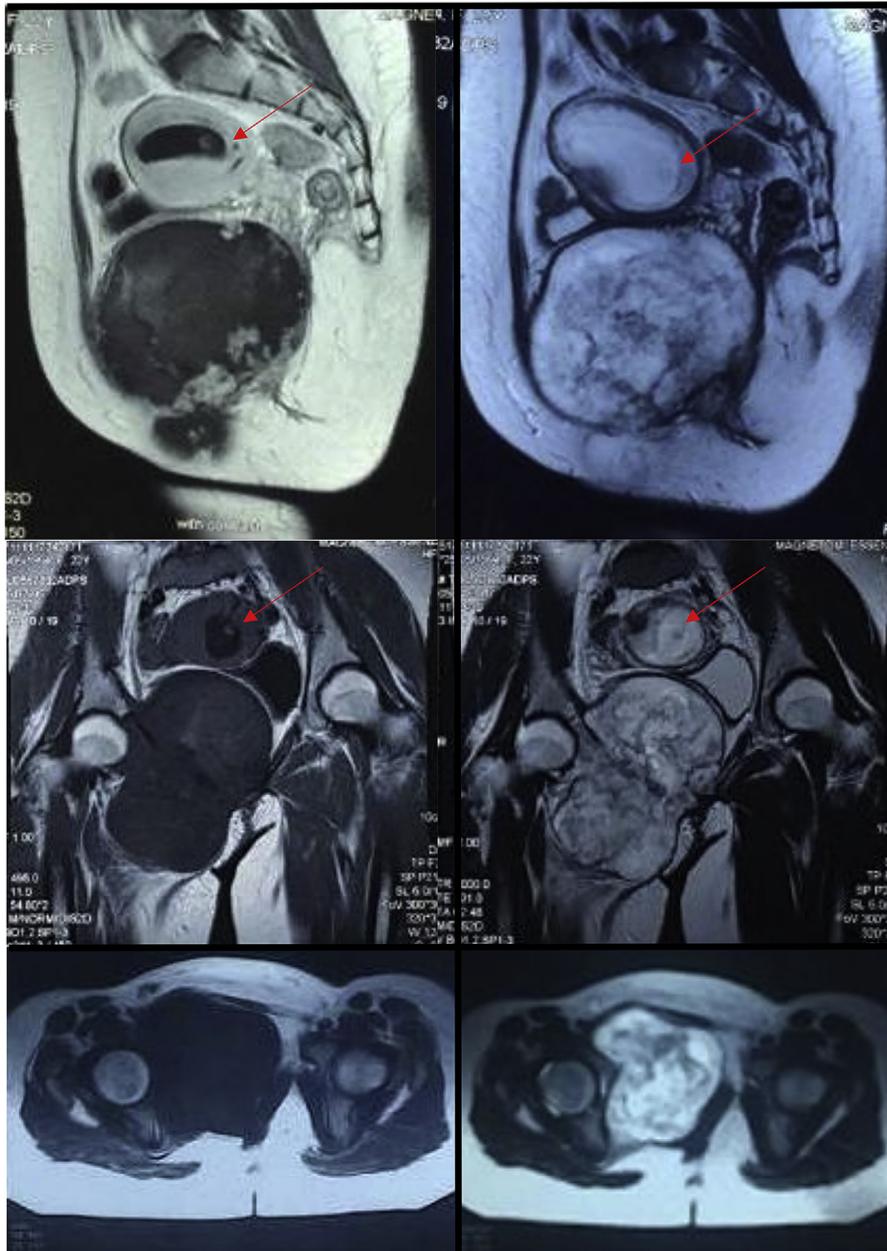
Pelvic MRI at 2 months pre-operative. Incidental finding of gestational sac (red arrow).
